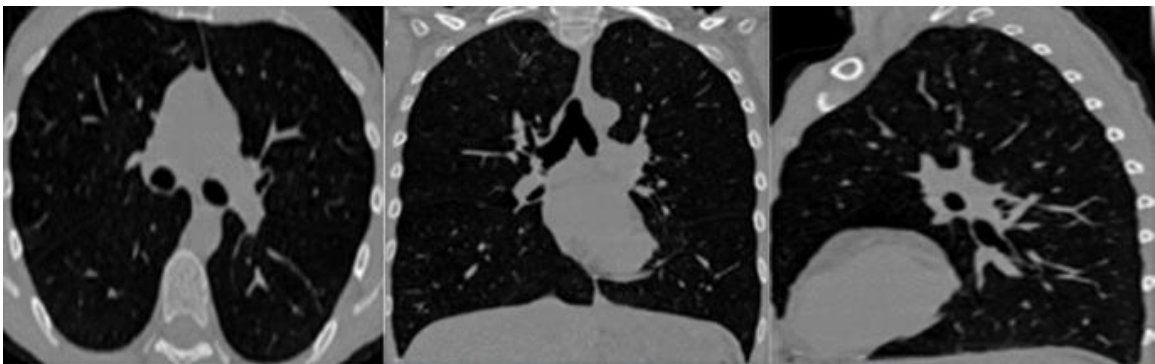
Typical axial, coronal, and sagittal views from the pulmonary CT scan
